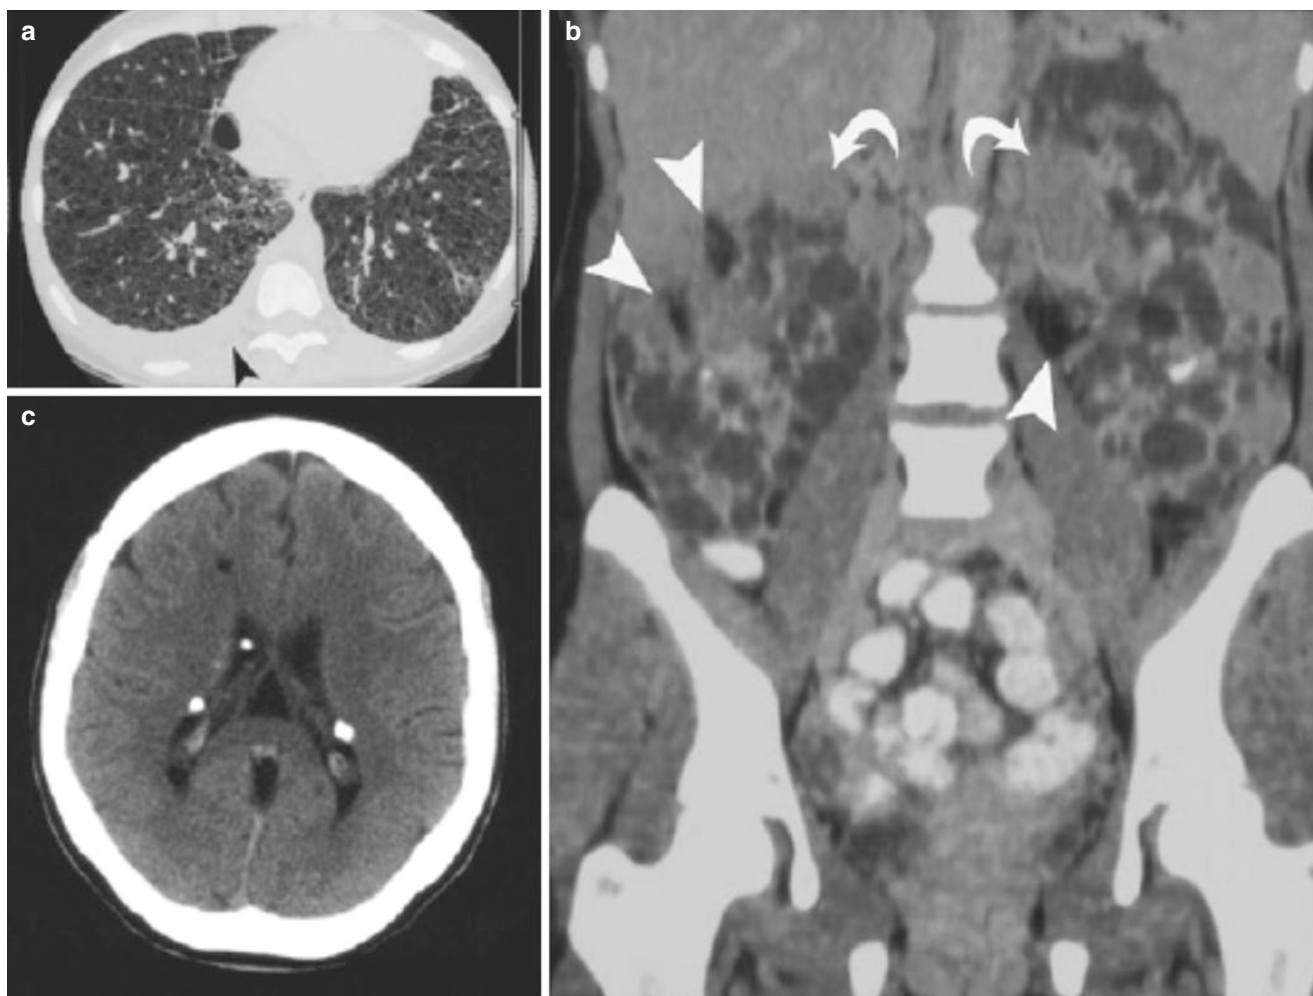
Lymphangiomyomatosis in a 29-year-old woman with tuberous sclerosis. (a) Axial HRCT image shows diffuse small cysts with imperceptible walls throughout both lungs. Note also the right pleural effusion (*arrowhead*). (b) Coronal enhanced CT image shows multiple fluid attenuation cysts throughout both kidneys along with foci
